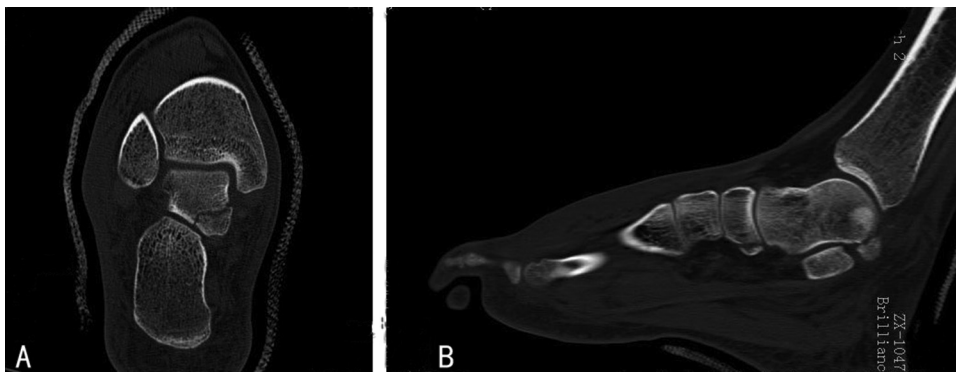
CT scan of coronary and sagittal view for the right foot showing two fractures of the entire posterior talar process and navicular fracture.
